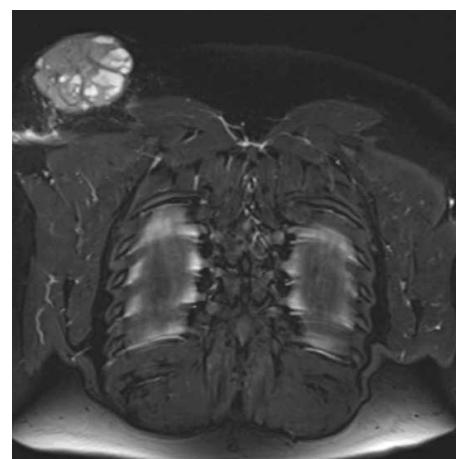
Axial T1 contrast-enhanced MRI, Figure 3: Axial DWI-ADC, and Figure 4: coronal STIR images showing a heterogeneous lesion with solid-cystic components in the subcutaneous tissue of the posterior aspect of the shoulder, measuring 7 x 5.5 x 4.7 cm. The solid component shows marked diffusion restriction. Areas of high T1 signal suggest hemorrhagic changes, and there is prominent enhancement with intravenous gadolinium. No metastases are observed on the remaining imaging studies.
